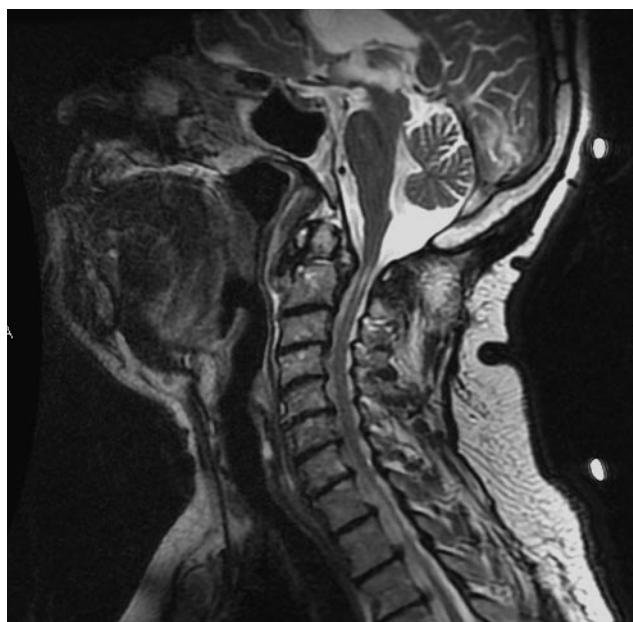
Sagittal T₂-weighted magnetic resonance imaging shows C1–C2 instability and myelomalacia at C2 level posterior to odontoid nonunion.
